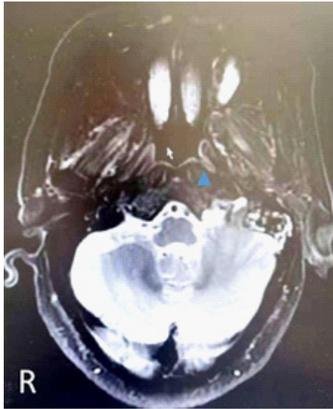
Representative coronal sections of a post antifungal treatment MRI nasopharynx with contrast demonstrating the nasopharyngeal space occupying disappeared (blue triangle Δ).
